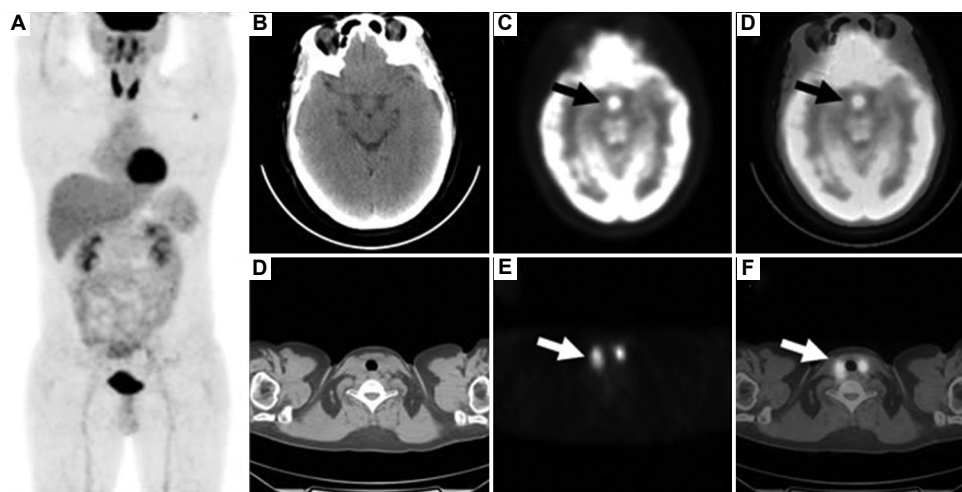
¹⁸F-FDG PET/CT findings in a patient with Langerhans cell histiocytosis demonstrating concurrent pituitary and diffuse thyroid hypermetabolism. (A) MIP image showing diffuse thyroid uptake and focal increased FDG activity in the pituitary region. (B) Axial CT of the brain demonstrating normal pituitary morphology. (C and D) PET and fused PET/CT images, respectively, of the brain, revealing markedly increased FDG uptake in the pituitary gland (black arrows, SUV_{max} = 12.9). (E) Axial CT of the neck showing residual thyroid tissue. (F and G) PET and fused PET/CT images, respectively, demonstrating diffuse thyroid hypermetabolism (white arrows, SUV_{max} = 11.3). These findings highlight that inflammatory or infiltrative disorders such as Langerhans cell histiocytosis may exhibit intense pituitary FDG uptake, potentially mimicking neoplastic lesions. This figure is adapted from Ju *et al.*,⁵ available under a Creative Commons Attribution (CC BY 3.0) license.
